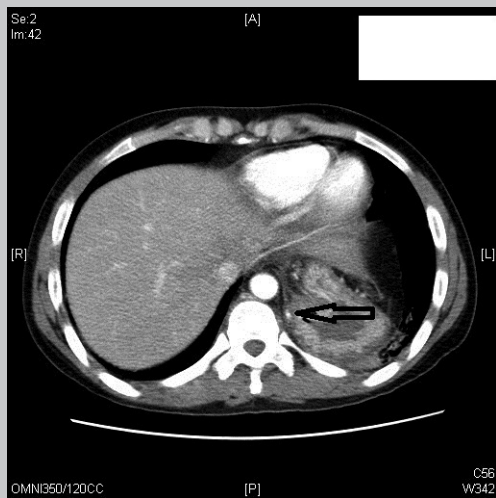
(top) and B. Computed tomography scans of chest and abdomen showing the artery travelling upward toward the thorax.
